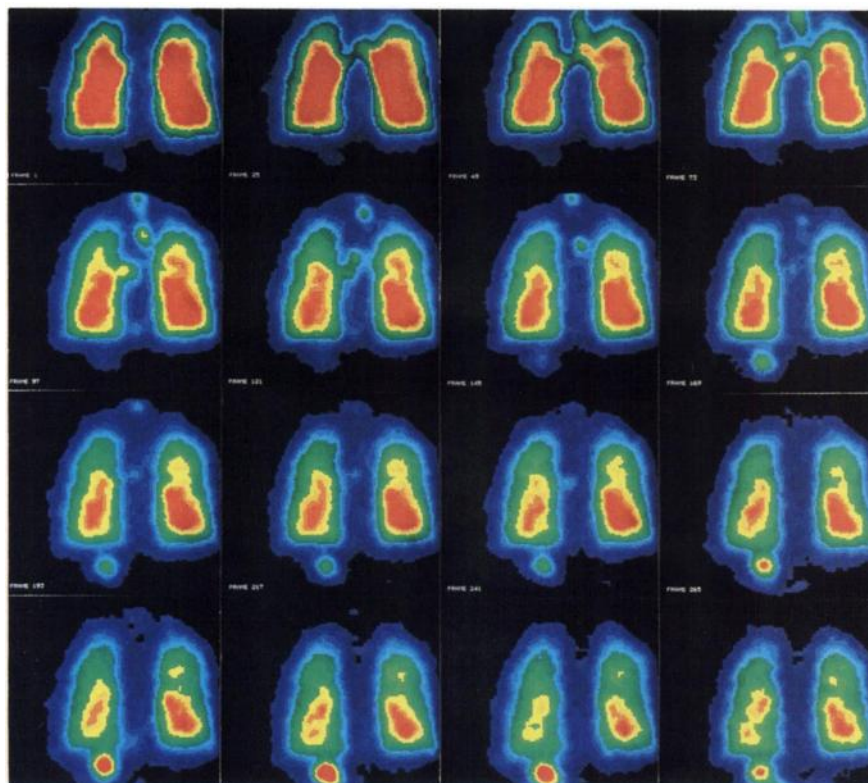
Aerosol inhalation cine-scintigraphy in a healthy control subject (type I). Since it was impossible to show 360 frames in this report, 16 frames were presented, 1 for every 24. The BRA ascended smoothly and rapidly in a continuous flow from bilateral main bronchi to the trachea. After reaching the larynx, it was swallowed into the stomach.
